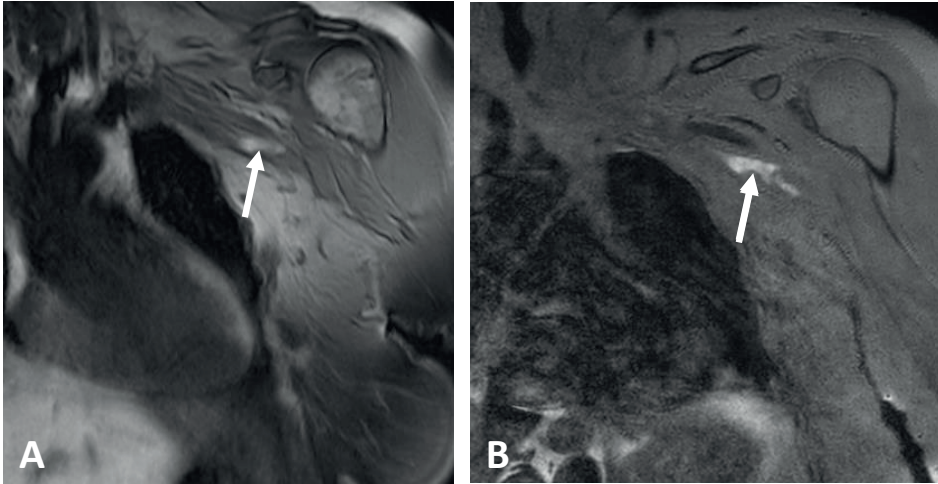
1B – Unenhanced MRI sequences: MRDTI (A) and 3D TSE-SPAIR (B) acquisitions of the upper extremities, coronal view.
